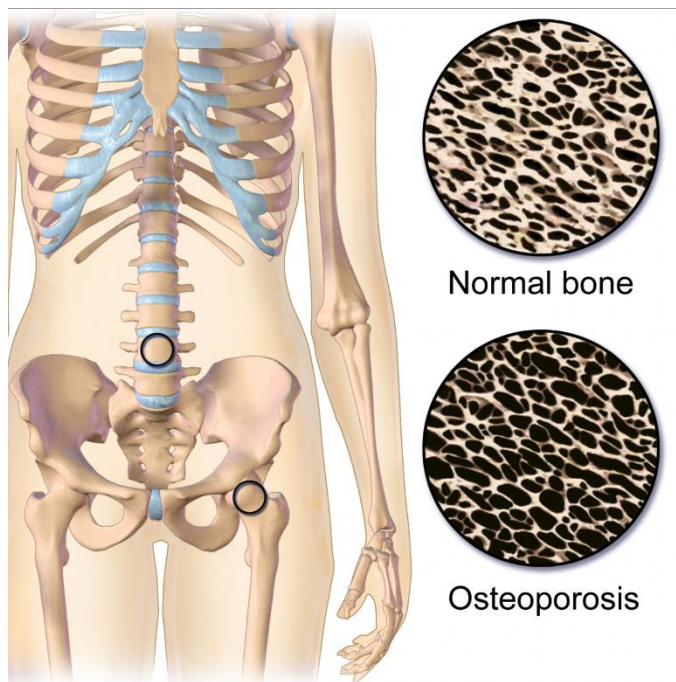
Osteoporosis. Dual-energy X-ray absorptiometry (DXA) is the gold standard technique for measuring bone mass. Measurements are usually obtained at the femoral neck and lumbar spine. Blausen Medical. Retrieved on 25 January 2016. Wikimedia Foundation. Creative Commons CC BY.
